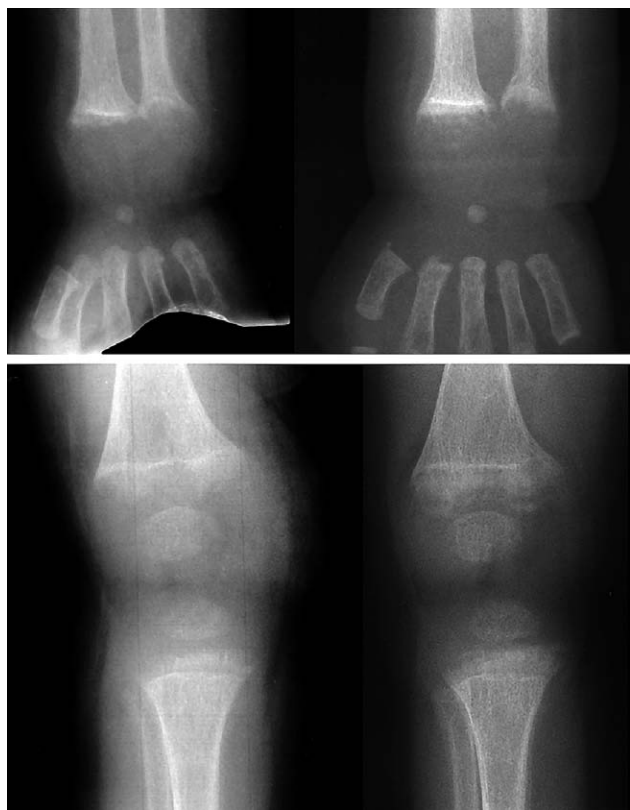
Radiographs of the right wrist (upper panel) and knee (lower panel) of a patient with PDDR (same as in Fig. 5). (Left) Before treatment; (right) after only 3 weeks of treatment, healing of rickets is well under way.
